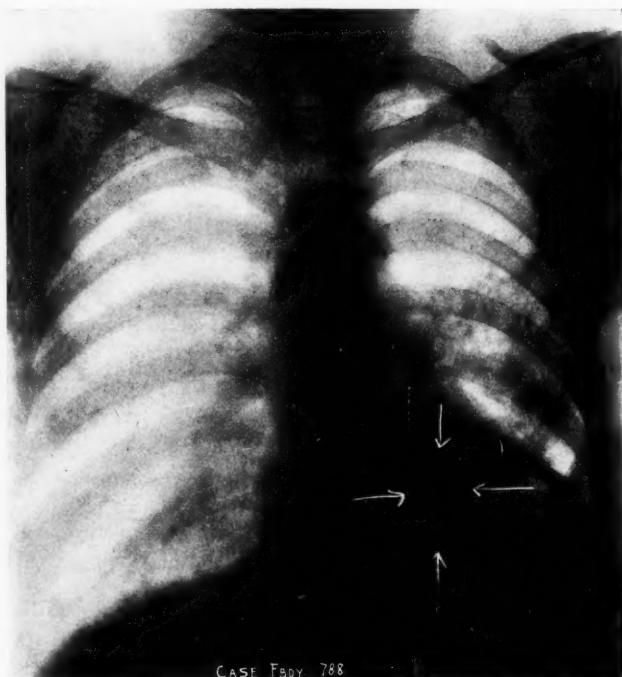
Case I (Fbdy. No. 788). Roentgenogram of a man aged twenty-eight years with abscess of the lung due to foreign body. Notwithstanding the foreign body is metallic it could not be shown through the heart and abscess shadows sufficiently strongly for half-tone reproduction. Foreign body removed by peroral bronchoscopy.
